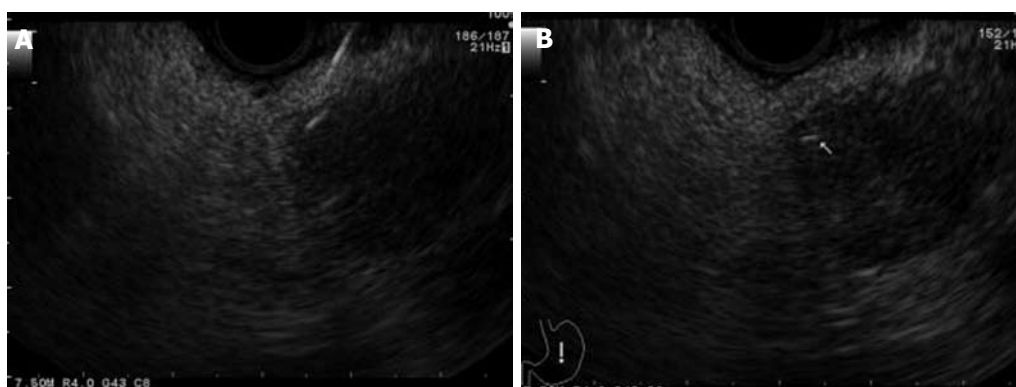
Endoscopic ultrasound-guided fiducial marker placement for locally advanced pancreatic cancer^[22].
